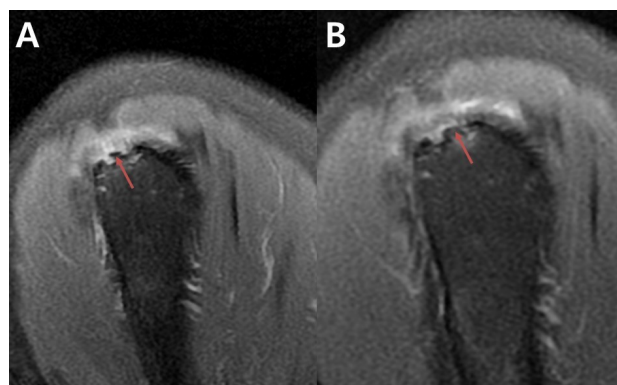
MRI imaging, sagittal view.
